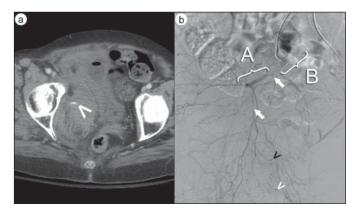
(a) Contrast-enhanced axial computed tomography image demonstrates right-sided intrapelvic hematoma with active contrast extravasation (white arrow). (b) Digital subtraction angiography of the right internal iliac artery demonstrates a few foci of active contrast extravasation from the presumed internal pudendal artery (open white arrowheads) and obturator artery (open black arrowheads), compatible with hemorrhage secondary to traumatic laceration. Distal right internal iliac artery (bracket A), unselectable, hemorrhaging right obturator artery (white arrows), and proximal right internal iliac artery (bracket B).
